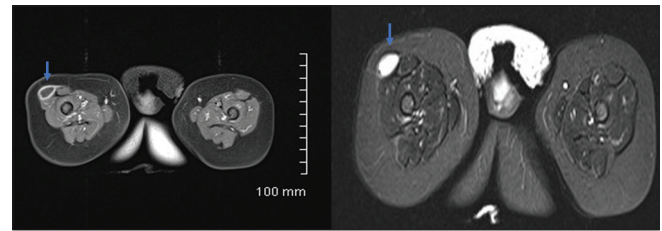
Multisequence magnetic resonance imaging of the thigh showing a T1 dark, T2/short-tau inversion recovery bright lesion, with rim enhancement (blue arrows)
